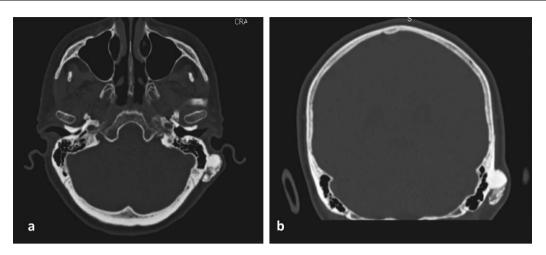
Non-contrast CT: axial (a) and coronal (b) sections showing the osteoma arising from the posterosuperior part of the left mastoid cortex.
